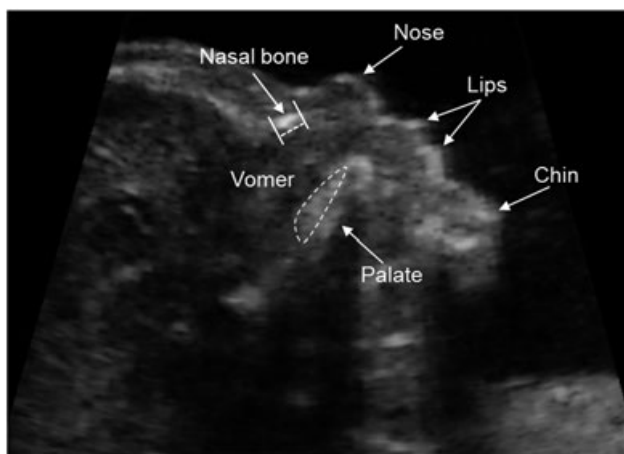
Ultrasound picture from a trisomy 21 fetus at 20 weeks demonstrating the exact midsagittal plane of the face with its sonographic landmarks and measurement of nasal bone length
